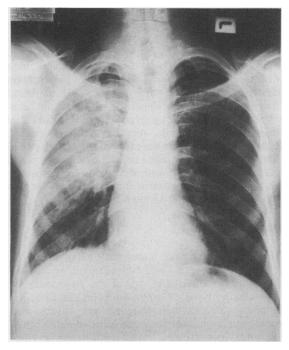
Chest radiograph on patient 5 at presentation; in the tropics these appearances would normally be considered a sufficient basis for the empirical treatment of tuberculosis.
